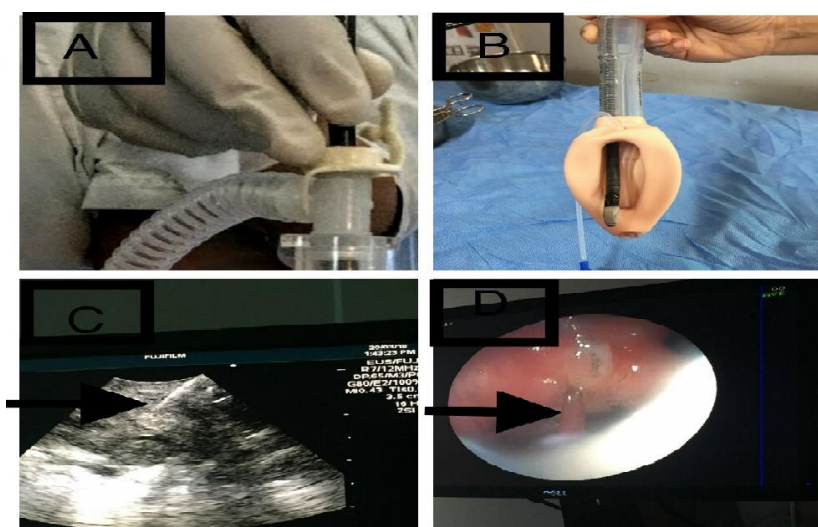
Insertion of EBUS probe through the catheter mount; B: emergence of EBUS probe through the proseal LMA; C: Ultrasound image of the needle during aspiration; D: Bronchoscopic view of the needle during aspiration
